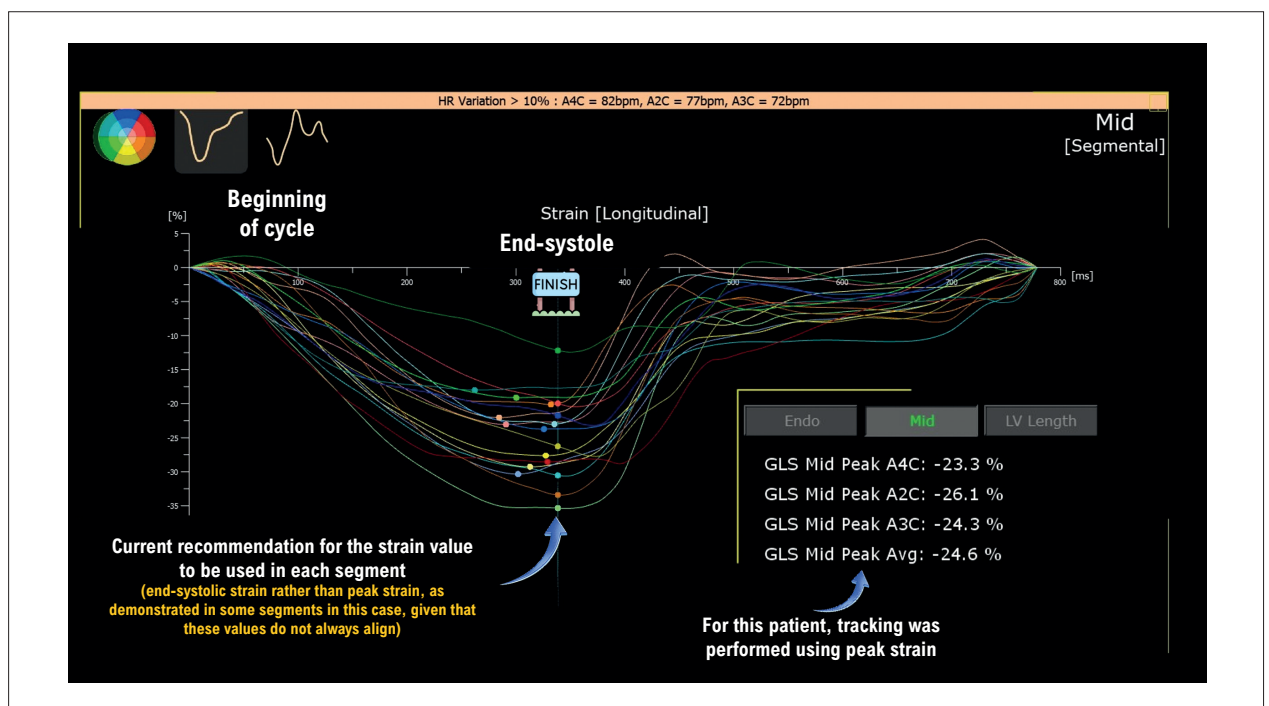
Assessment of strain curves and description of the values to be used. According to the Clinical Applications of Strain Echocardiography: A Clinical Consensus Statement from the ASE Developed in Collaboration with the EACVI of the European Society of Cardiology, the final value used should be the one shown at the end of ventricular systole, which does not always align with peak strain.^{1,4}
